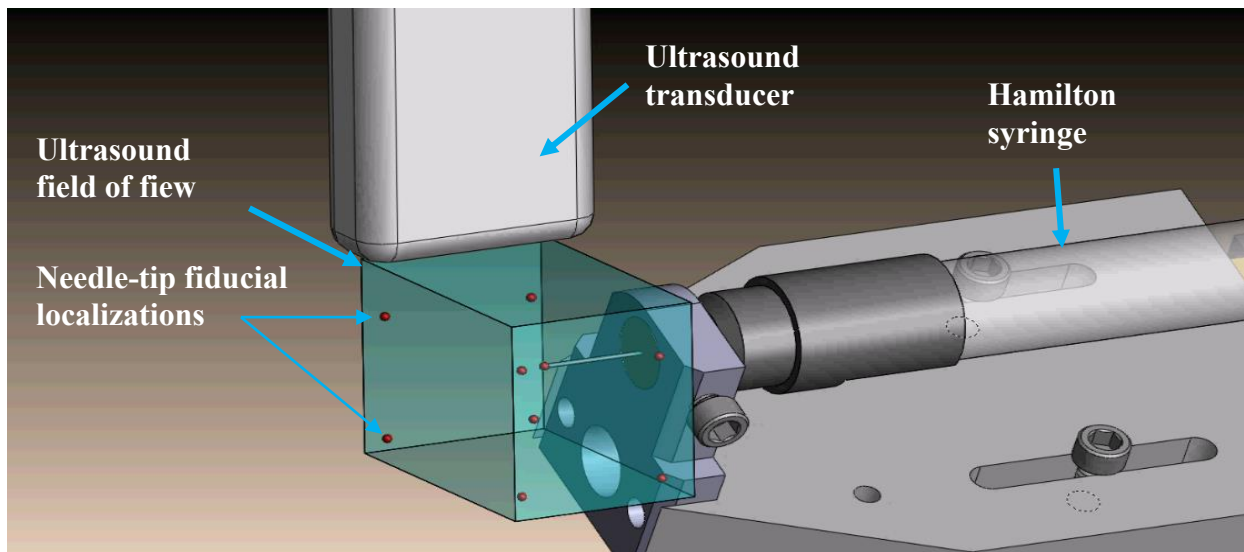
The robot stages are used to move the needle tip to multiple positions in the 3D ultrasound field of view. At each point, the needle tip's lumen centre is localized to collect a fiducial point in ultrasound, while also recording the stage coordinates. Eventually, a common point set is obtained to perform a rigid-body point-based registration.
